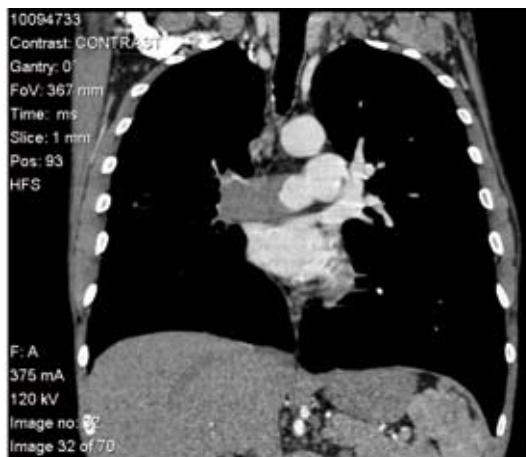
Thoracic - CT angiogram showing right ventricular thrombus.
